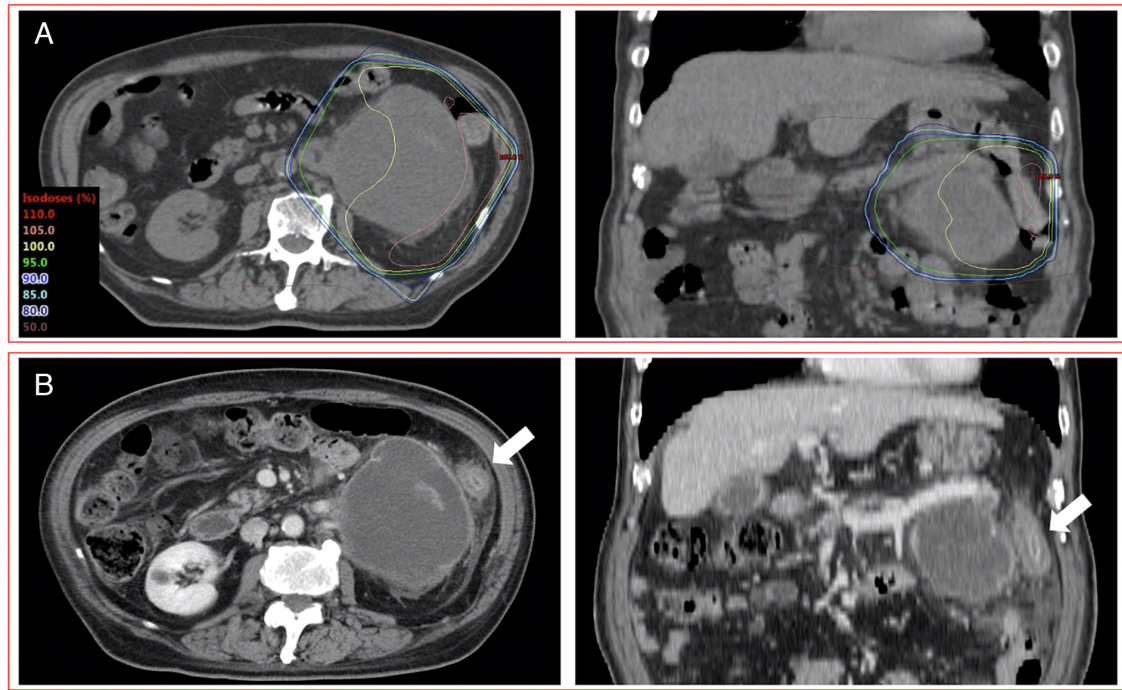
A patient (75 years, male) with grade 4 RIE after PRT involving the large bowel and administration of ICIs. (A) CT images displaying dose distribution of PRT to an adrenal metastasis (20 Gy in 5 fractions); (B) Contrast-enhanced CT images acquired 28 days after completion of PRT. This patient with grade 4 RIE exhibited segmental and circumferential bowel wall thickening, pericolic fat stranding and mucosal hyperenhancement in the area of the irradiated field (white arrow) as seen on CT imaging after receiving combination therapy of PRT and ICIs. Left panel showed transverse images and the right panel showed coronal images. RIE, radiation-induced enterocolitis; PRT, palliative radiotherapy; ICIs, immune checkpoint inhibitors; CT, computed tomography.
